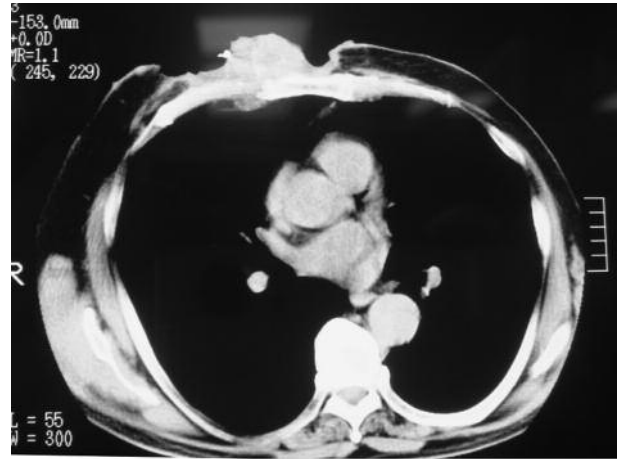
Preoperative CT showing the infiltration of the ribs and invasion of the deep ulcerating lesion into the anterior mediastinum.
